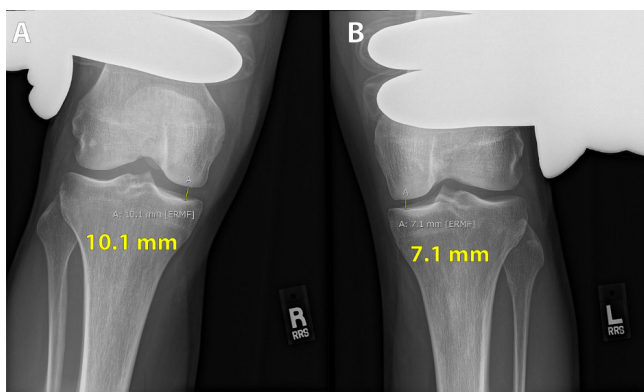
Valgus stress radiographs of the right (A) and left (B) knee at 20° of knee flexion which show a 3.0 mm difference of side-to-side medial compartment gapping compared to the uninjured left knee. LaPrade et al described a threshold of 3.2 mm of side-to-side differences of medial compartment gapping for the diagnosis of a grade III medial collateral ligament (MCL) tear.<sup>44</sup>
